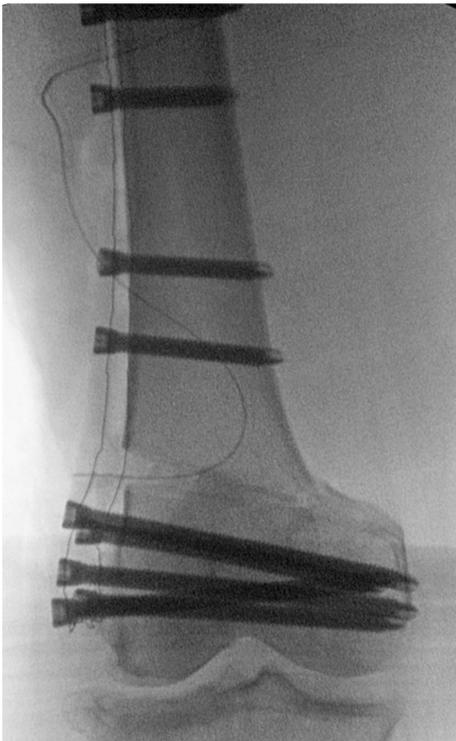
By way of comparison, this radiograph of a different patient shows a displaced fracture of the medial cortex that occurred intraoperatively.
